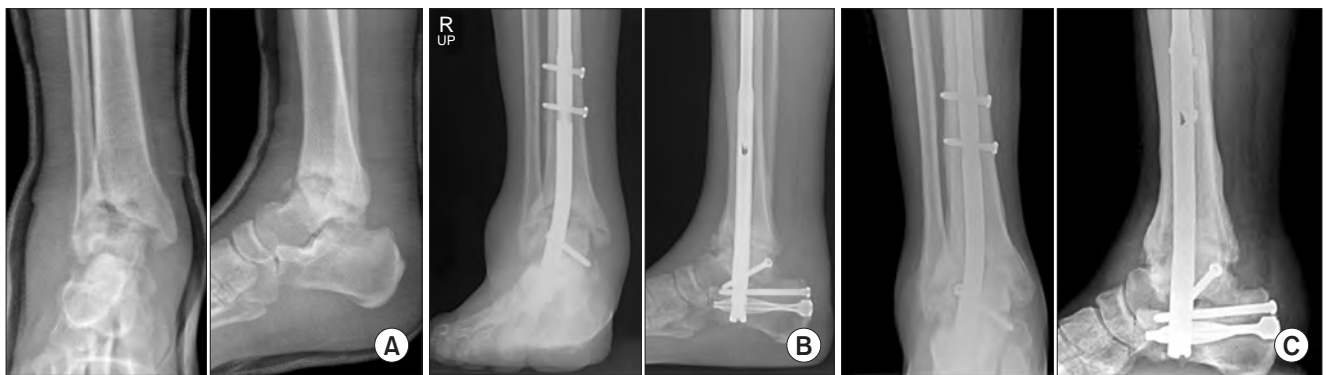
Pre- and postoperative anteroposterior and lateral radiographs of the ankle of a 54-year-old male patient who underwent tibiototalocalcaneal arthrodesis with a retrograde intramedullary nail. (A) Severe valgus deformity without significant bony loss of the talar body. (B) Anteroposterior and lateral radiographs of the weight-bearing ankle 3 months postoperatively. (C) Bony union was observed on the anteroposterior and lateral radiographs of the ankle 6 months postoperatively.
